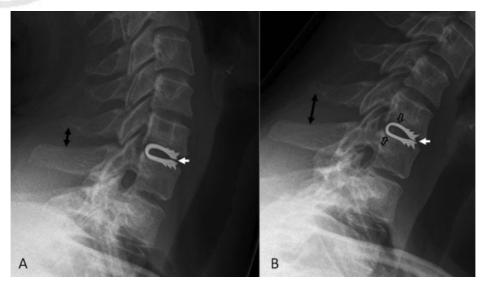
Lateral radiographs from the 12-month follow-up showing (A) extension and (B) flexion after dynamic cervical implant surgery on the C6-C7 segment. The changing distances between the limbs of the implant (white arrows) and the C6-C7 spinous processes (black arrows) indicate preserved motion in the index segment. However, lucent lines (open arrows) indicate nonintegration of the implant into the bony end plates.
